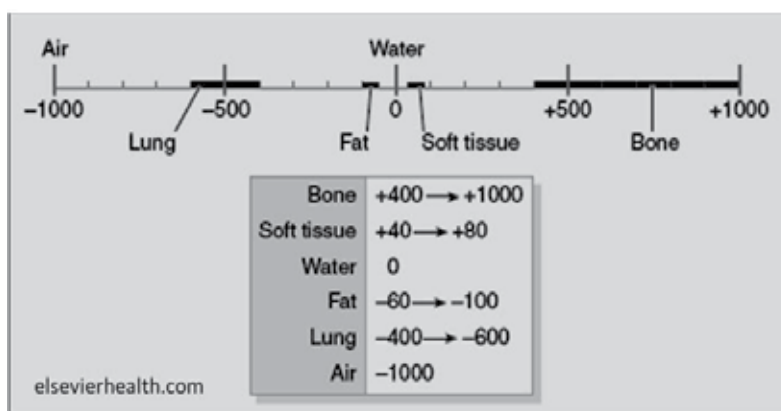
CT Numbers = Hounsfield Units.
